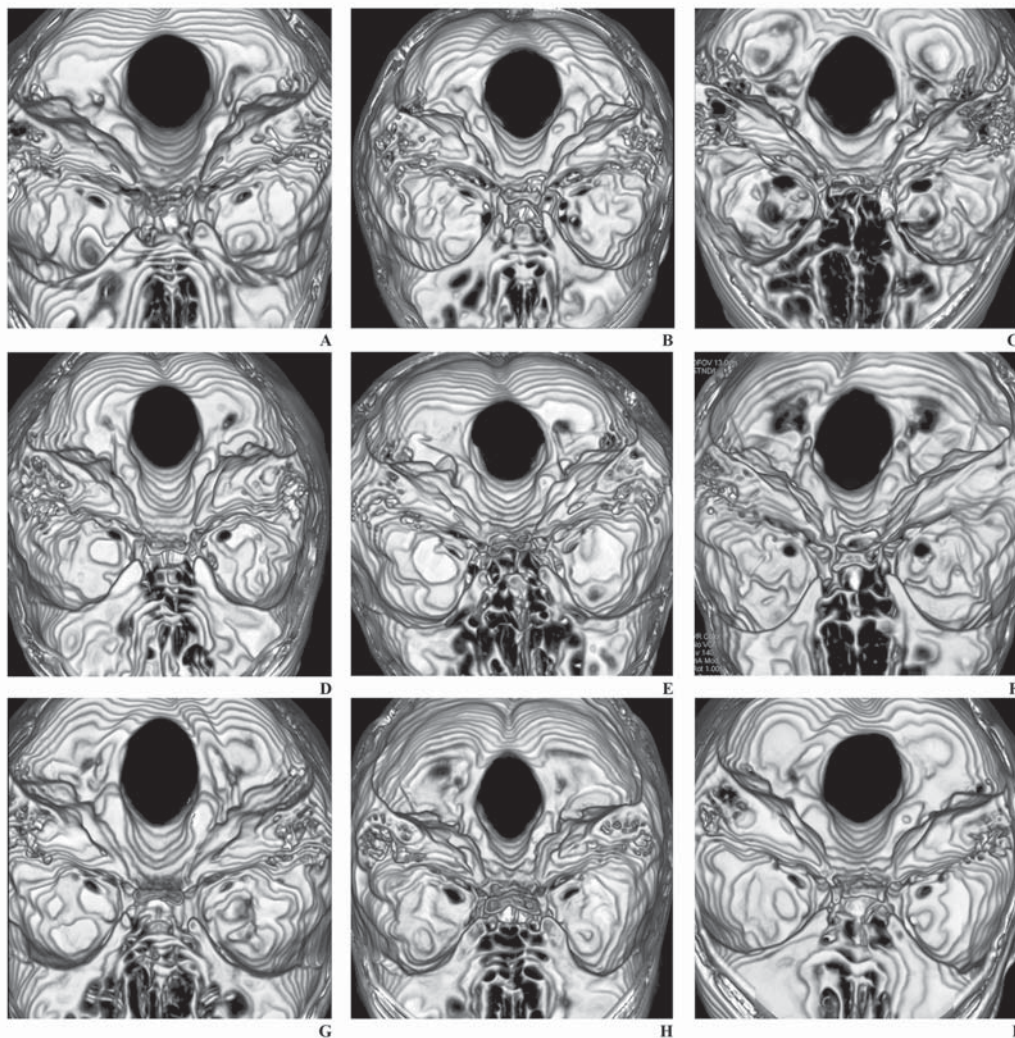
Morphology of the foramen magnum in the pseudo-3D CT reconstruction; A. Circular; B. Two semicircle; C. Heart-like; D. Wide oval; E. Bi-rounded oval; F. Ventrally wide oval; G. Bi-pointed oval; H. Dorsally convergent oval; J. Asymmetrical two semicircle.
